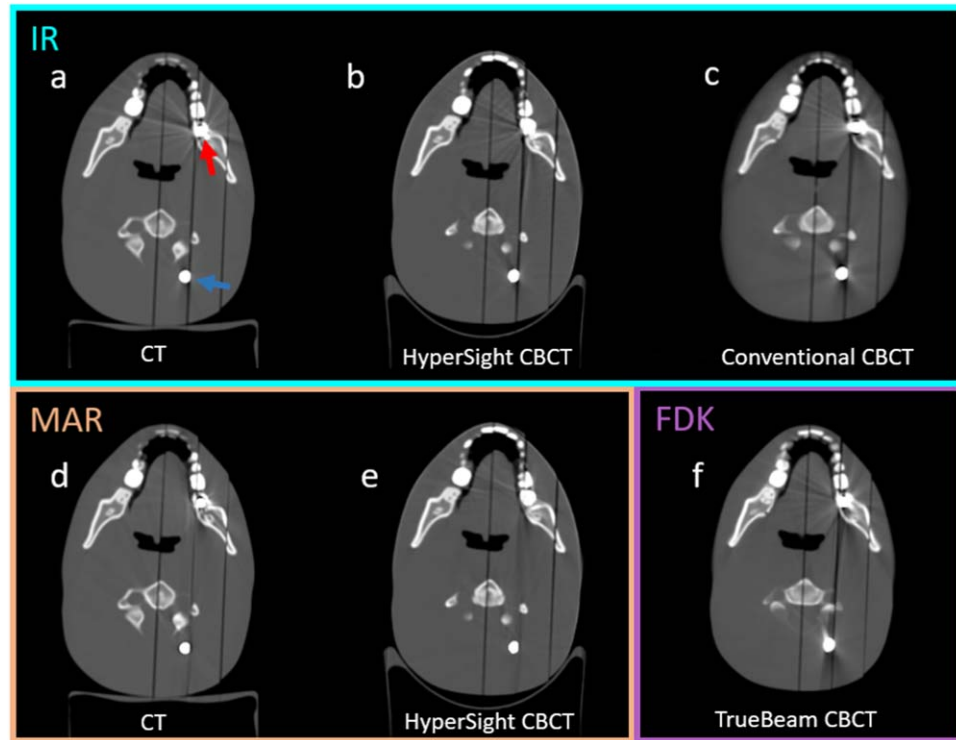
Visualization of an axial slice containing metal artifacts arising from tooth T (red arrow) and spine implant (blue arrow) after reconstruction with iterative reconstruction (IR) for (a) CT, (b) HyperSight CBCT, and (c) Regular CBCT. In addition, it shows metal artifact reduction (MAR) reconstruction for (d) CT and (e) HyperSight CBCT, and FDK reconstruction for (f) TrueBeam CBCT. A more detailed version of the artifacts around the dental implant and spine implant can be found in figure S2 in the supplementary material. A window level setting of $[-700, 1000]$ was used for all images.
